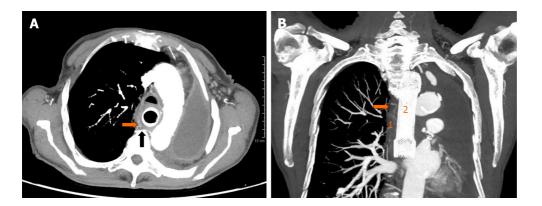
Arterial phase contrast-enhanced computed tomography. A: Axial view showing the tortuous and dilated right bronchial artery (orange arrow) originating from the right third posterior intercostal artery (black arrow); B: Coronal view showing delation of the tissue planes between the right bronchial artery (orange arrow) and the thickened middle esophageal wall (1), with correct placement of the esophageal metal stent (2).
